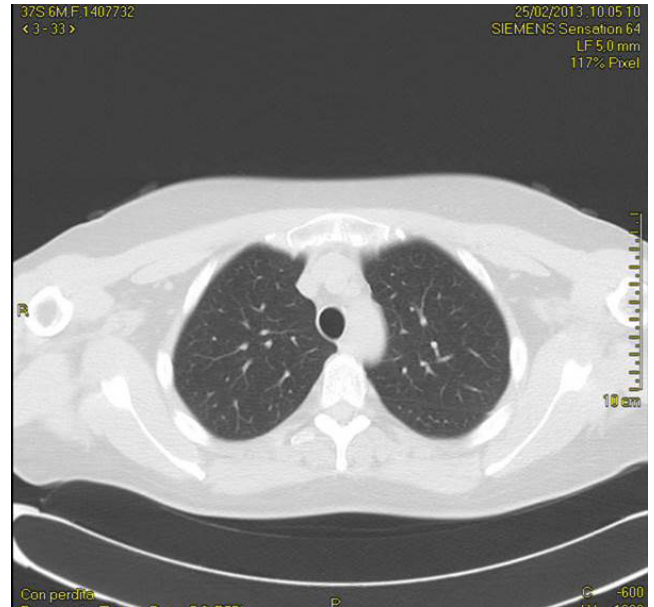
CT scan showing resorption of air after 1 month
